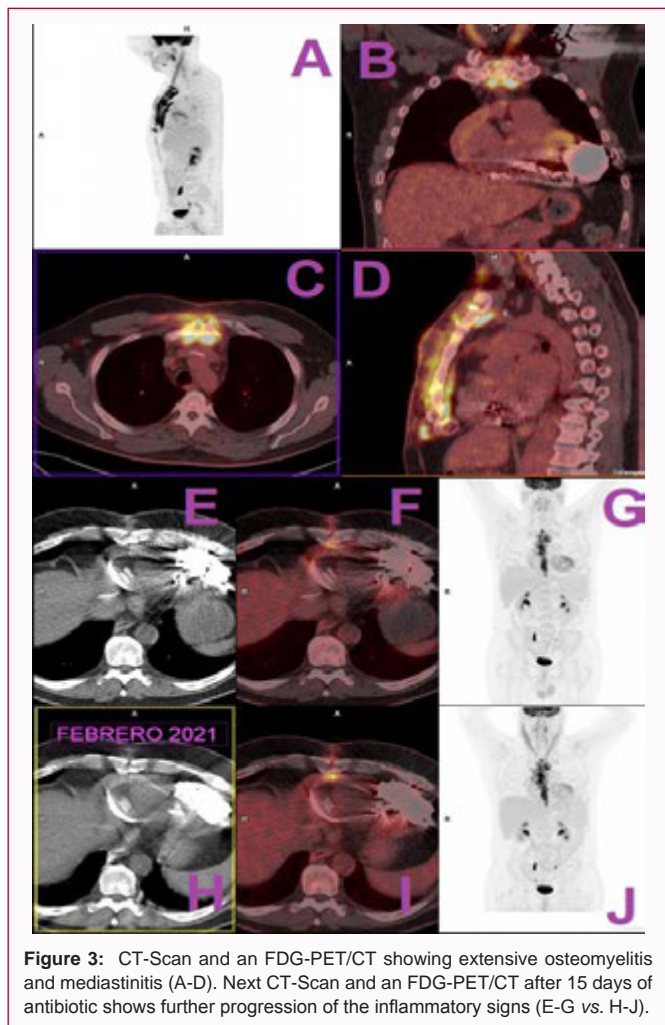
CT-Scan and an FDG-PET/CT showing extensive osteomyelitis and mediastinitis (A-D). Next CT-Scan and an FDG-PET/CT after 15 days of antibiotic shows further progression of the inflammatory signs (E-G vs. H-J).
